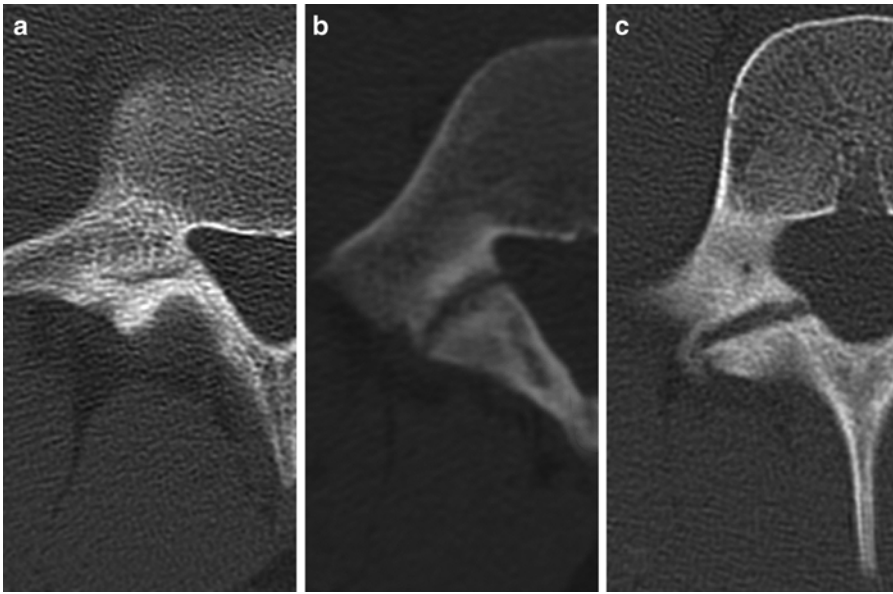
CT demonstrating early, terminal, and progressive right-sided spondylolysis. (a) Early lesions involve a small fissure or hairline defect through the pars. (b)
